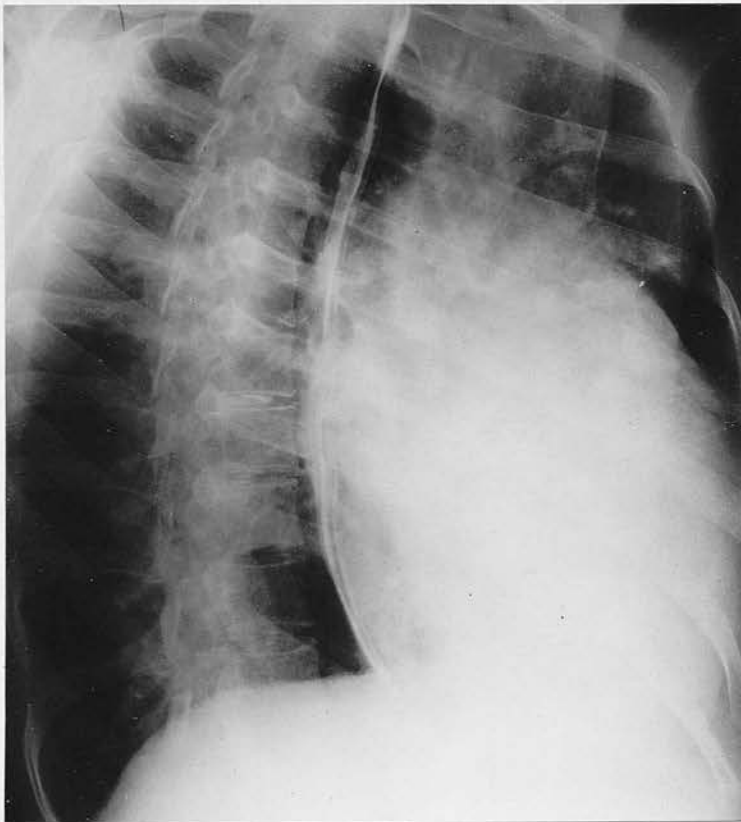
Radiograph of Case 75. Stomal Ductus with Shunt Reversal.
